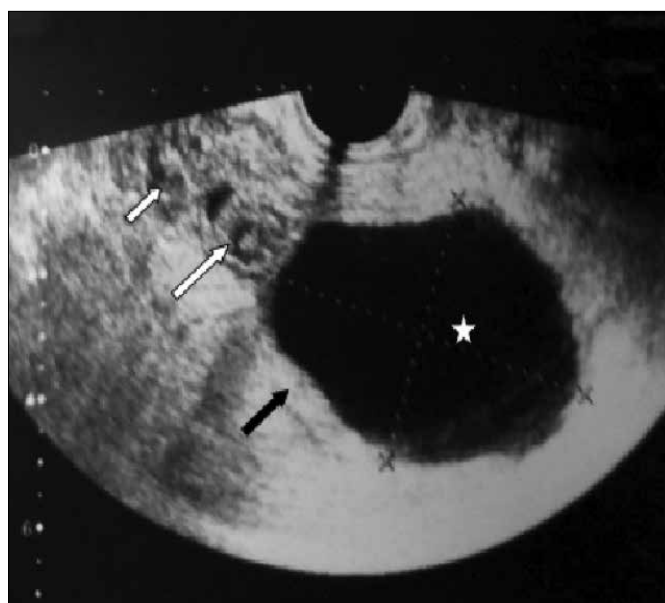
Transvaginal grey scale sonography. Hypoechoic, thick-walled (hyperechoic) (black arrow) cystic mass (asteriks; left dilated tuba uterina) extended from right to the midline with minimal free fluid around the mass. The ovaries are shown at the upper right corner (small white arrow). Torsion/rotation area adjacent to tuba uterina is demonstrated between dilated tuba and the ovary (big white arrow; mass image which is formed from concentric circles, whirlpool sign)
